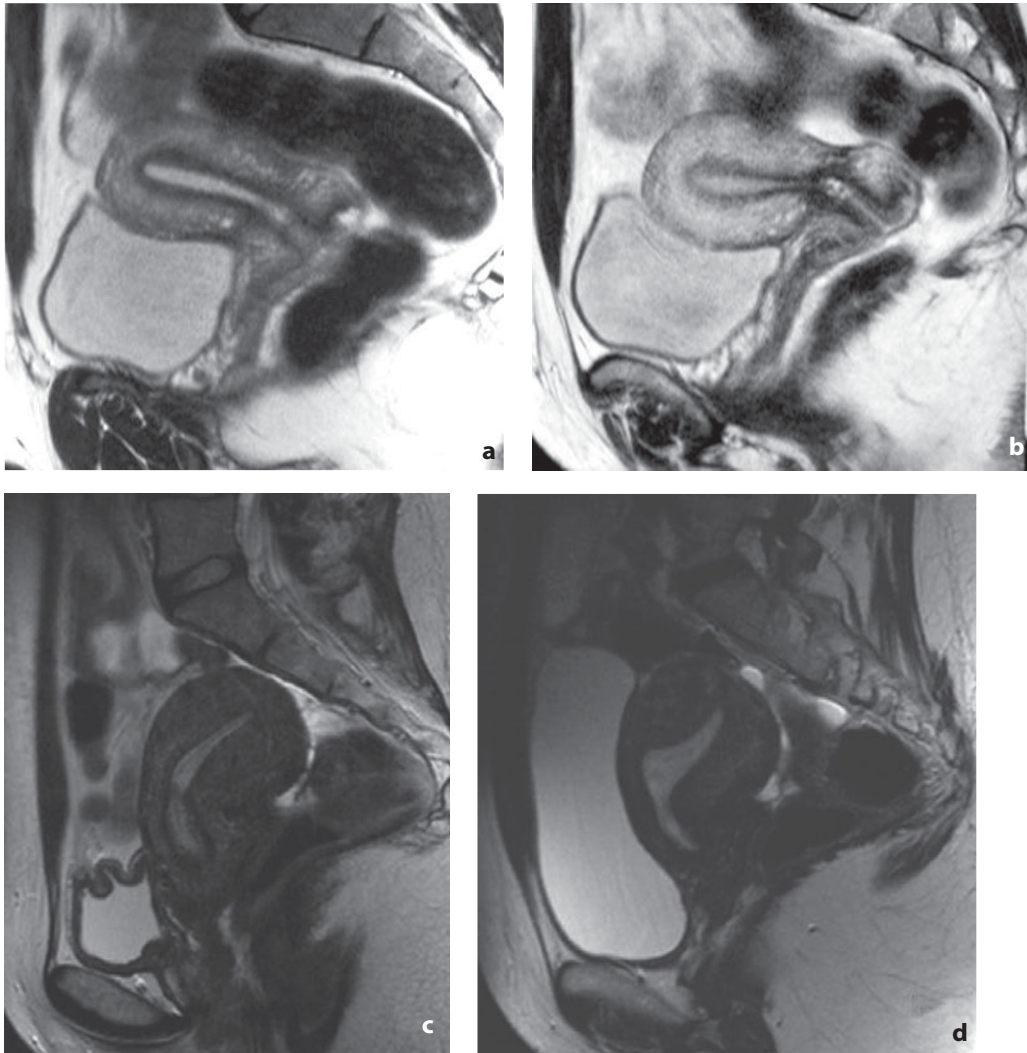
Magnetic resonance. Normal functional anatomy of the endometrium. T2-weighted sagittal images. a Follicular phase. b Luteal phase in which a slight increase in the thickness of the endometrial cavity can be appreciated with an increase in the signal of the myometrium. The increase in the thickness of the endometrium is more evident in another patient with a retroverted uterus, where image c was acquired in the follicular phase and d in the luteal phase
